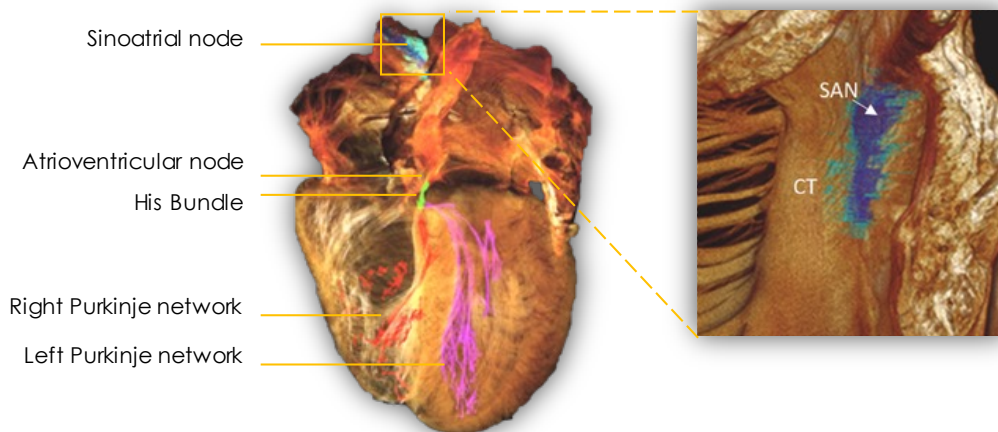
Components of the cardiac conduction system determined by micro-computed tomography. SAN: sinoatrial node, CT: crista terminalis. Modified from [145] under CC-BY license.
